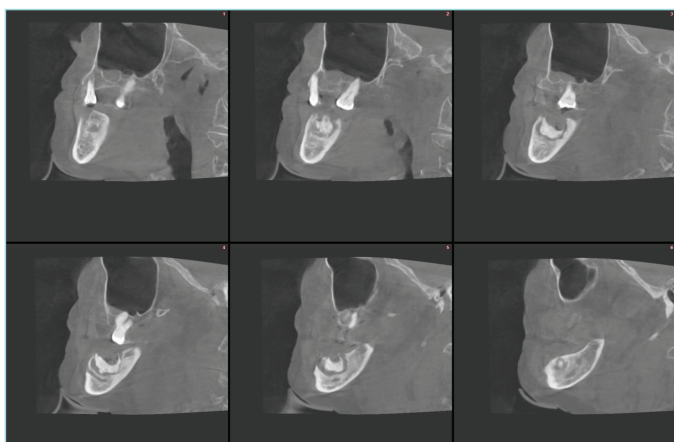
Sagittal view of the case in CBCT.
